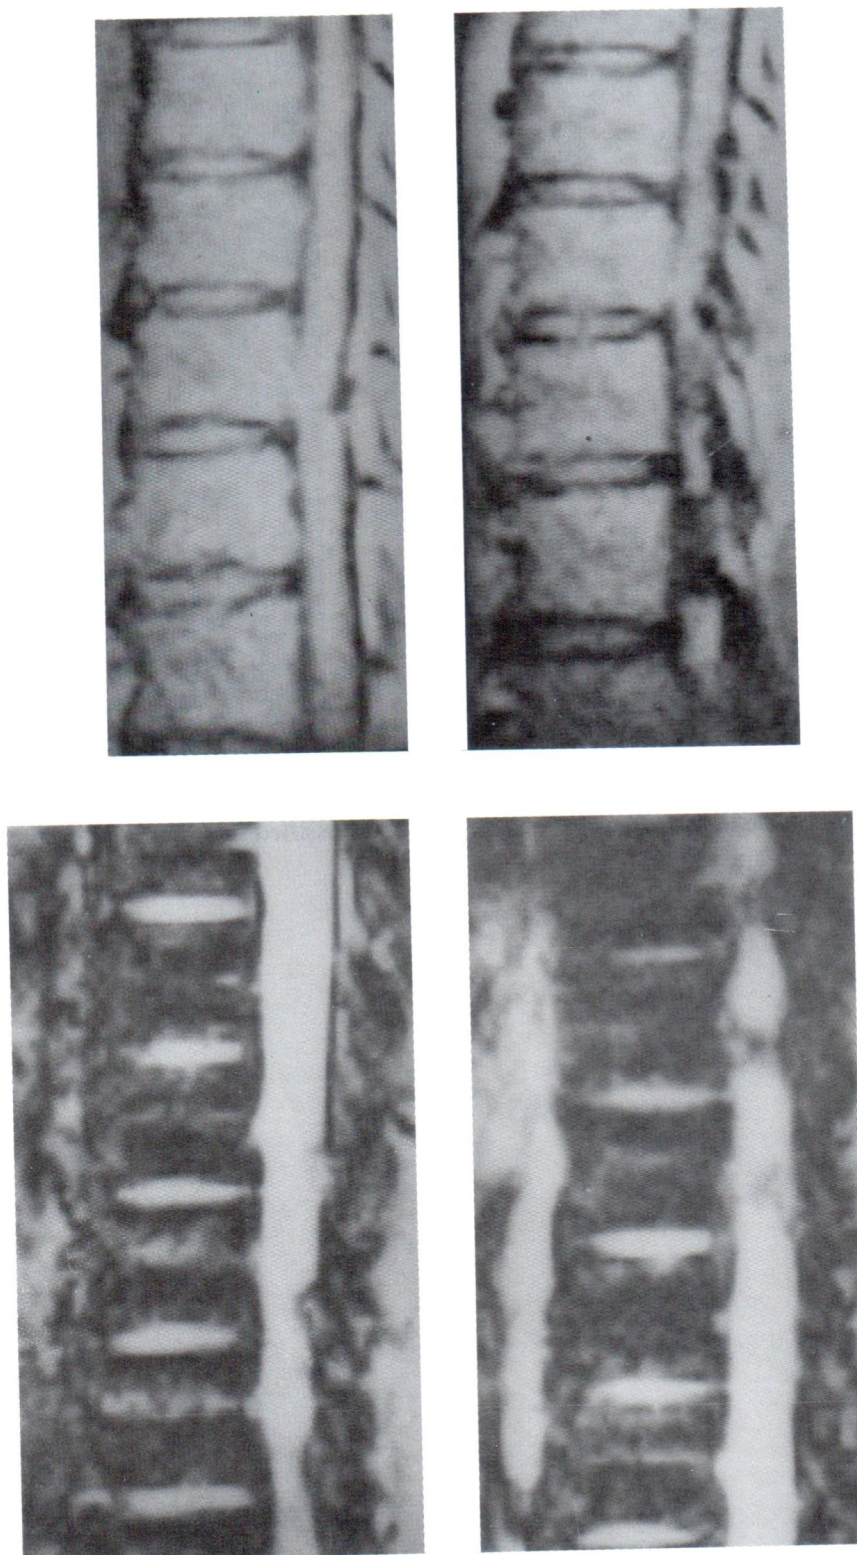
T1WI, T2WI-sagittal view MRI study of the thoracic spine showed low signal ligamentum flavum on both T1WI and T2WI at multiple levels.
